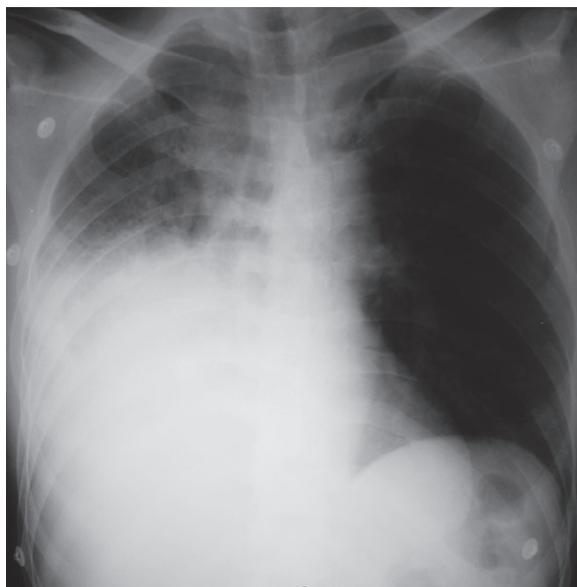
Portable chest X-ray: a large ill-defined opacity in the right hemithorax obliterating the right cardiac border. Right-sided pleural effusion.
